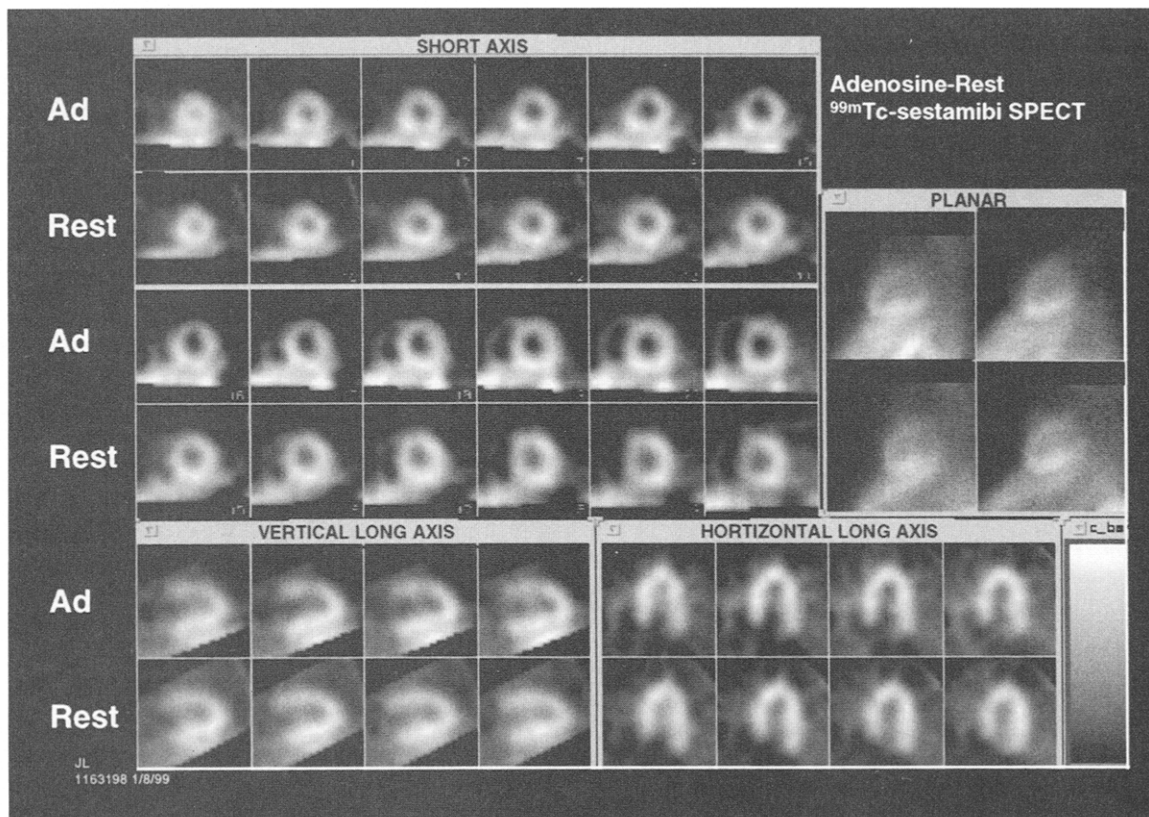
Adenosine stress and rest ^{99m}Tc sestamibi SPECT images of a 38-year-old obese woman with Cushing's disease, hypertension, and chest pain. The patient was unable to perform even low-level exercise. Note marked hepatic tracer uptake with artifactually high counts in the inferior wall, making it difficult to interpret the images. In addition there is some breast attenuation of the anterior wall. There is relatively less uptake in the anterior wall, which may be an artifact caused by high liver activity and breast attenuation. Gated SPECT imaging showed normal wall motion and thickening and normal left ventricular ejection fraction.
